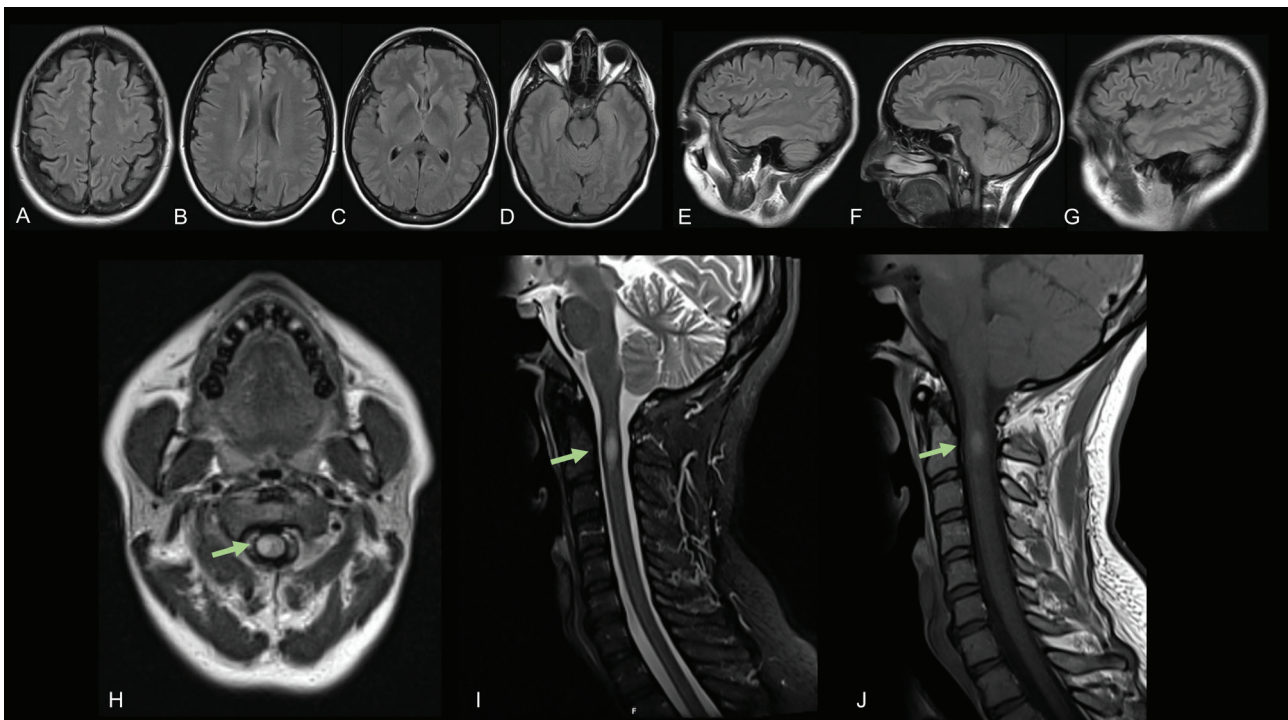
(A-D) Axial and (E-G) sagittal T2-weighted fluid-attenuated inversion recovery (FLAIR) images depicting sparse and unspecific small round hyperintensities. (H) Axial T2-weighted and (I) sagittal T2-weighted showing a partial myelitis encompassing right lateral funiculi at C2 level (green arrows). (J) Sagittal T1-weighted sequence showing central gadolinium enhancement.
